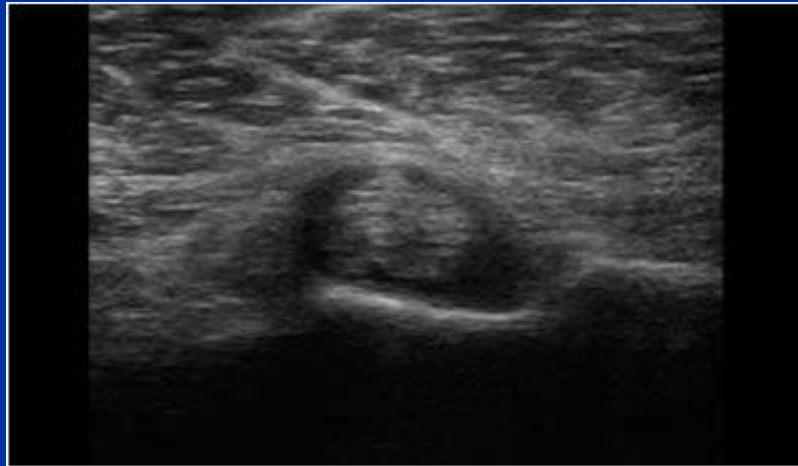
Image source <http://www.ultrasoundcases.info/>, <http://www.essr.org/cms>
